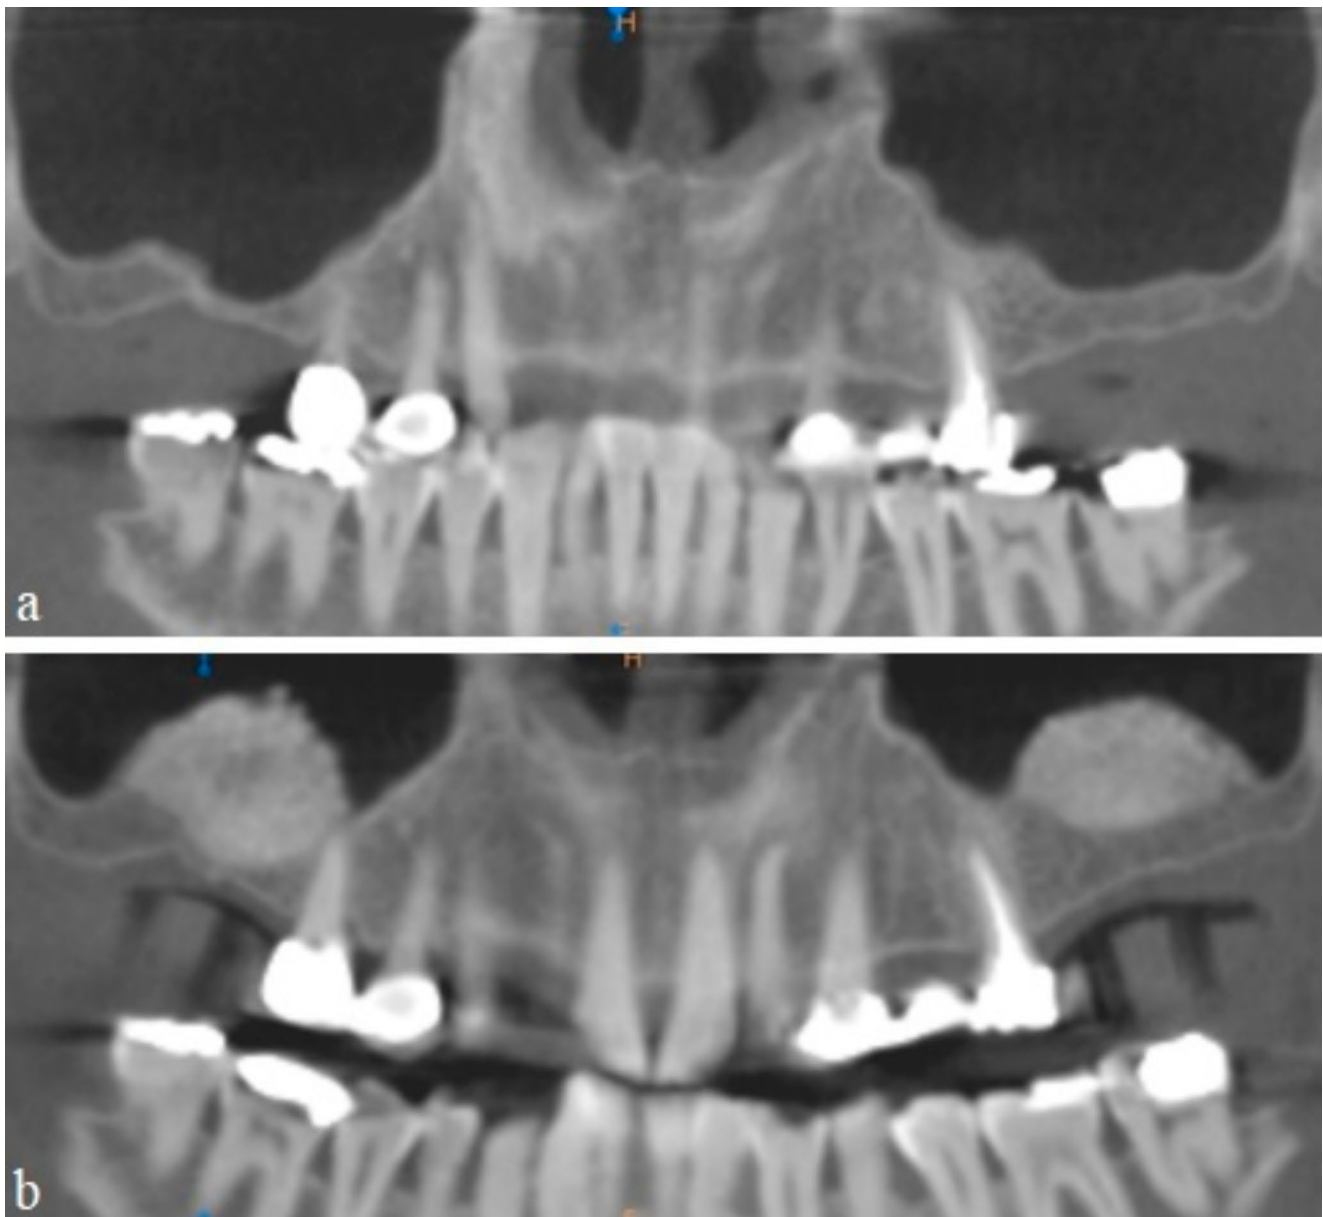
(a) Panoramic CBCT view showing atrophic posterior maxilla on both right and left sides. (b) Panoramic CBCT view of the same case showing the 6-month results of a bilateral MSFA procedure
